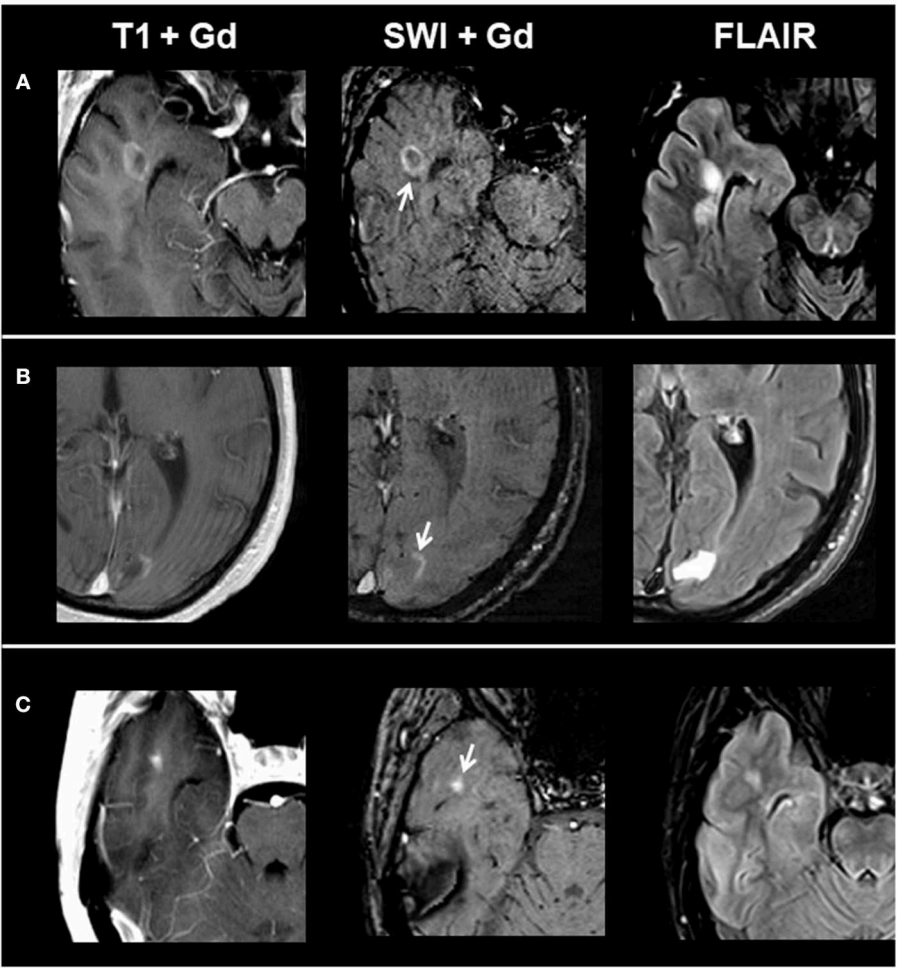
From left to right: representative post-contrast T1, post-contrast SWI, and FLAIR images of acute contrast-enhancing lesion subtypes. (A) Ring-shaped contrast enhancement, (B) peripheral contrast enhancement, and (C) homogenous contrast enhancement. SWI, susceptibility-weighted magnetic resonance imaging; FLAIR, fluid-attenuated inversion recovery.
